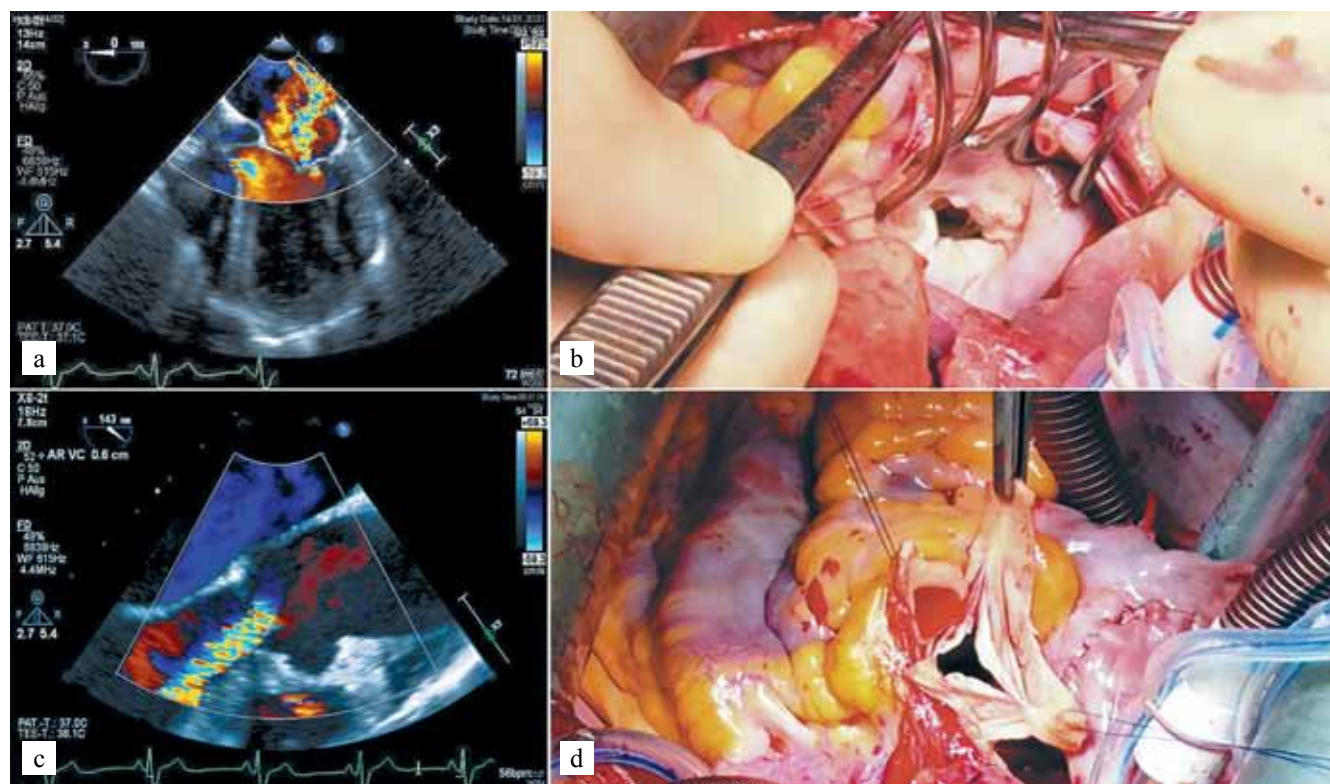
Transesophageal echocardiography and intraoperative findings of the mitral (a, b) and aortic (c, d) valves
